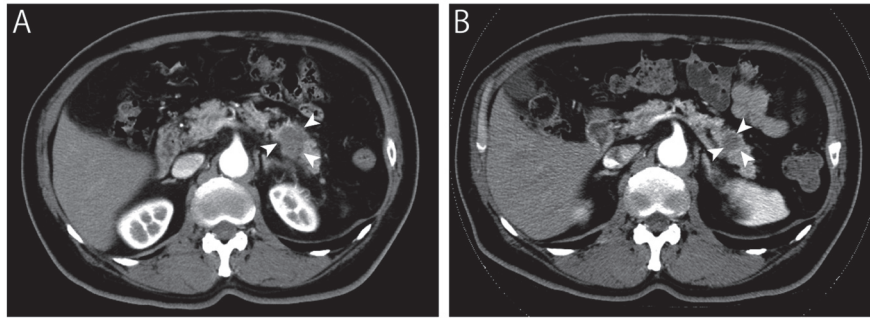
Case 1: Contrast-enhanced computed tomography (CT) findings.
